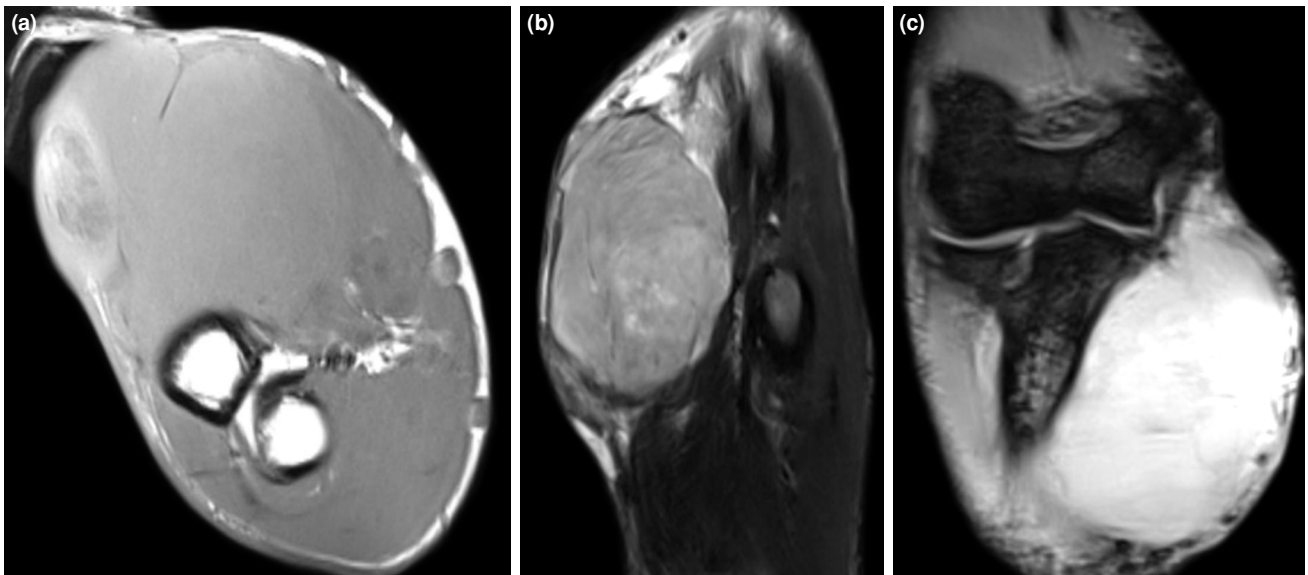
(a) Transverse, (b) sagittal and (c) coronary sections of magnetic resonance imaging of a malignant peripheral nerve sheath tumor demonstrating the proximity of neurovascular structures.
